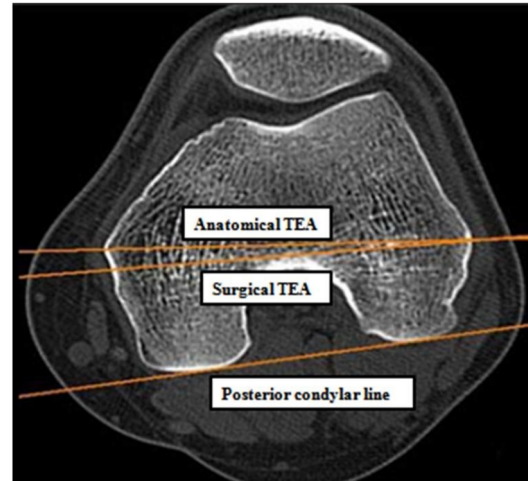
Landmarks applied to determine rotational profile on CT scan
